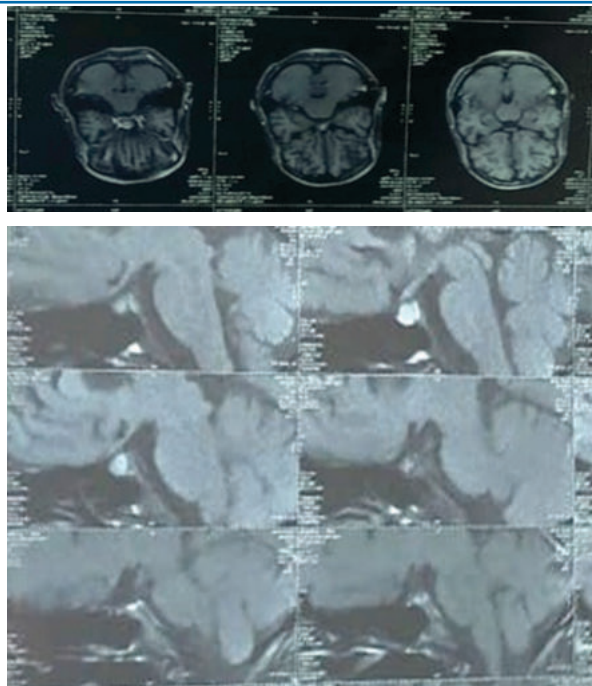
MRI Brain Showing T1 Hyperintense and T2 Hypointense Signal Suggesting Subacute Pituitary Haemorrhage
